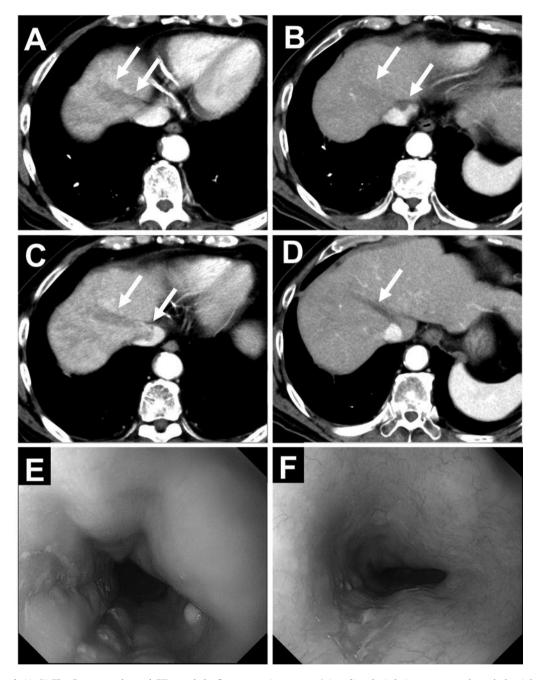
Case 3. (A, B) The Contrast-enhanced CT revealed a 5-cm tumor in segment 4, invading the inferior vena cava through the right hepatic vein, with hyperenhancement in the arterial phase (arrow). (C, D) The contrast-enhanced CT after two months showed a partial response (arrow). (E) EGD revealed a shallow depressed lesion in the upper esophagus. (F) EGD at seven months after the initiation of chemotherapy showed slight improvement.
